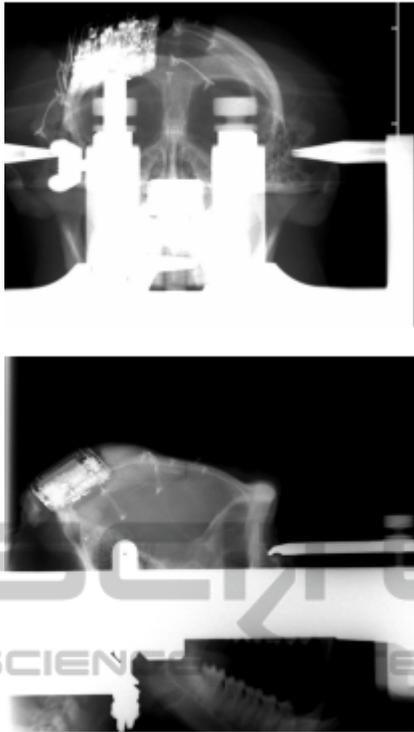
Post-op radiographic image of the device.
